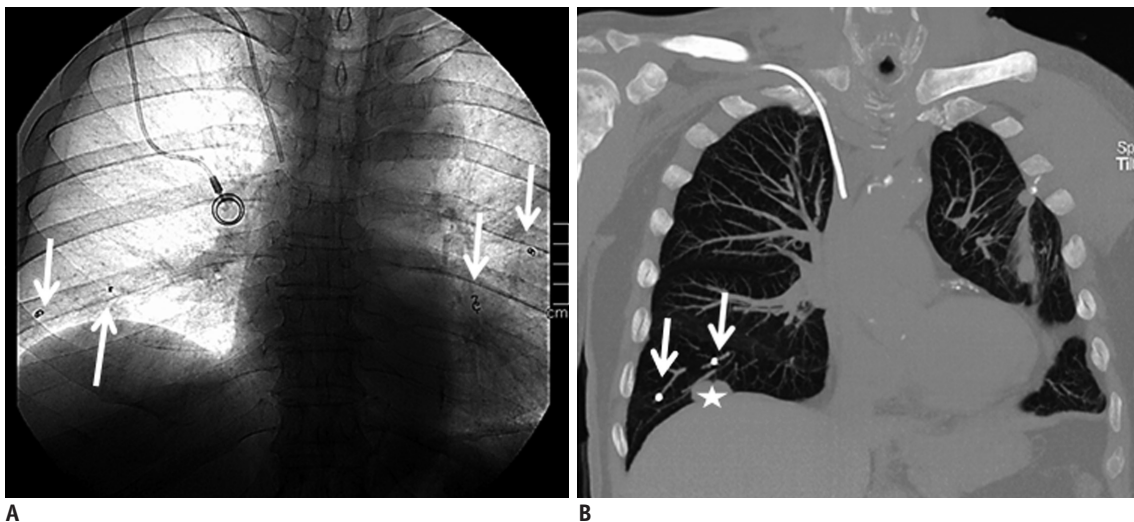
72-year-old male with metastatic adenocarcinoma (patient No. 5). A. Digital fluoroscopic image shows endovascular coils (arrows) which were placed into both lungs in single procedure. Tumors in both lungs were treated with CyberKnife. B. Coronal maximum intensity projection CT image shows two endovascular coils (arrows) in right lung, which were adequately placed in vicinity of tumor (star).
